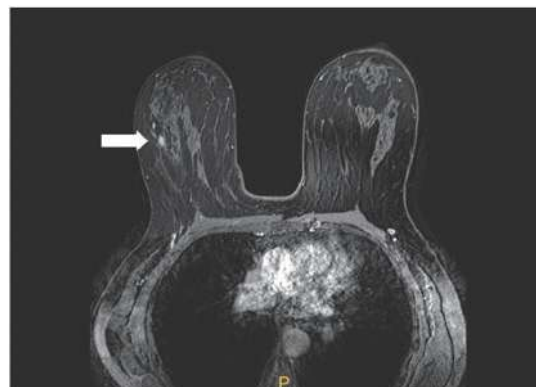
Breast MRI in a High-Risk Patient (BRCA1 Gene Carrier)
